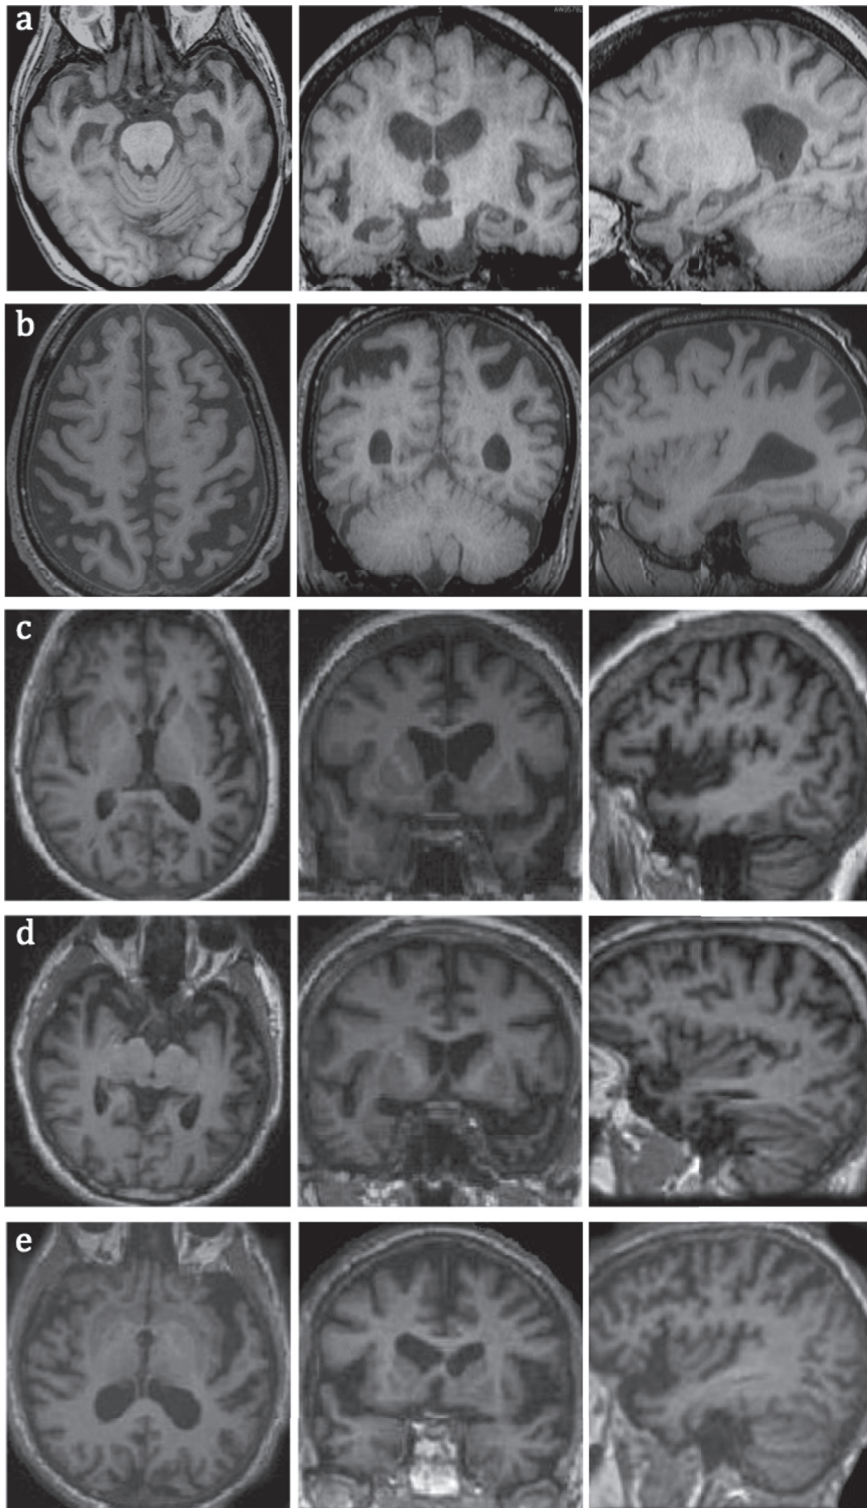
MRI images of common types of dementia in axial, coronal, and sagittal planes, a) early AD with hippocampal and MTL atrophy; b) PCA with superior posterior parietal lobes atrophy; c) logopenic variant of PPA with atrophy in left temporoparietal junction; note more prominent left sided atrophy of posterior and lateral temporal lobes; d) semantic variant of PPA with atrophy in anterior and lateral temporal lobes; e) non-fluent variant of PPA with left frontal operculum and insular atrophy.
